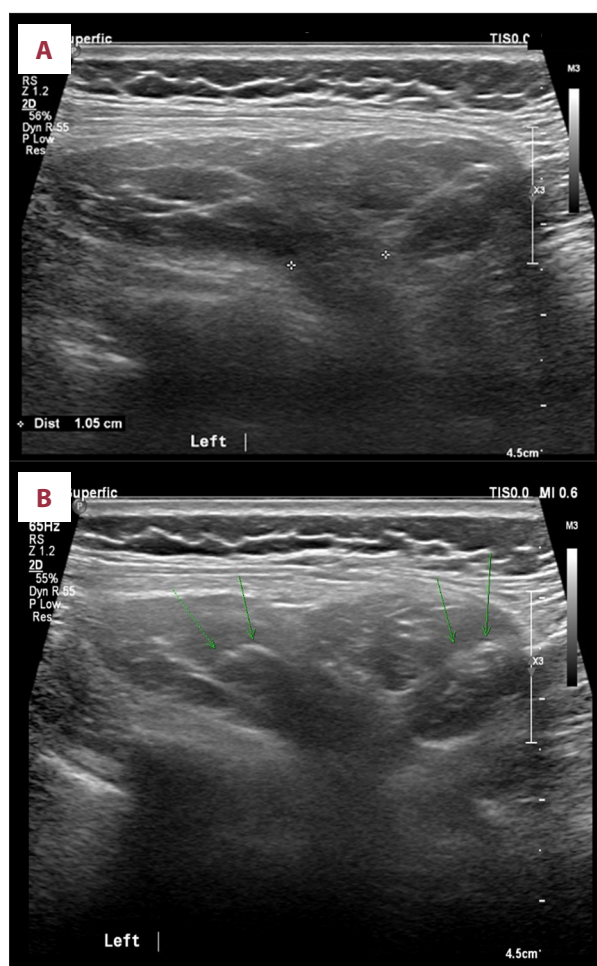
Lumbar ultrasound at rest (A) and during sitting position (B, C) showing separation of the muscle with herniation of fat and the bowel loops seen during the sitting position (arrows indicate the bowel).
